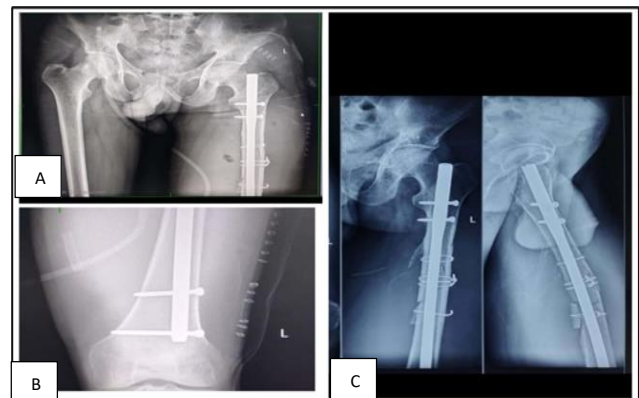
(A-C): Immediate post operative X-rays, showing follow up X-rays and arrow showing stent in situ.
